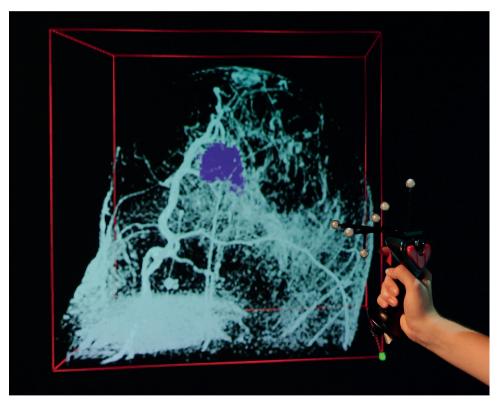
The I-Space creates an interactive three-dimensional (3D) image of the contrast-enhanced preoperative MRI dataset. Automatically the tumor is colored, and the volume is measured by V-Scope volume rendering application based on grey level differences.
